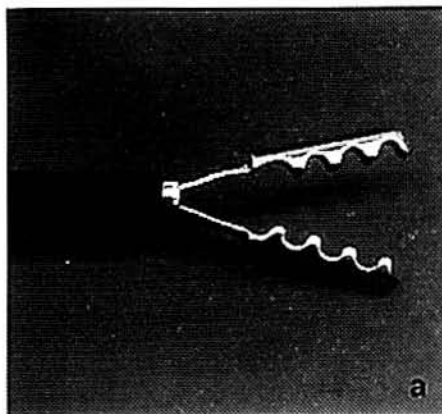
A Nitinol grasper, designed for endoscopic gall bladder surgery, is shown optically (a) and in an MRI image while testing in a grapefruit (b).
